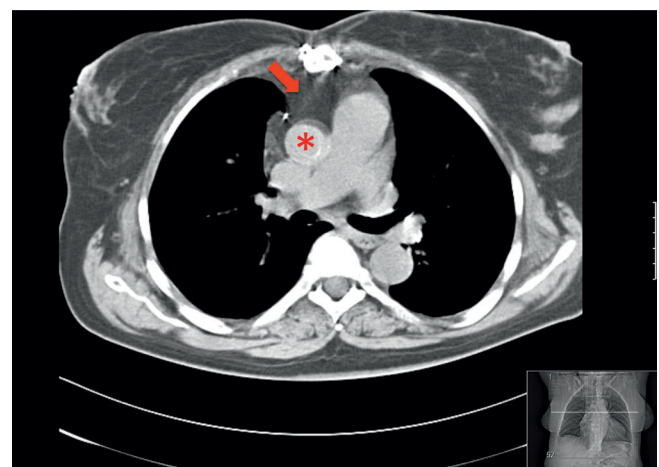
Computed tomography 3 years postoperatively. (Red arrow) The omental wrap. (Red asterisk) The new aortic prosthesis covered by the omentum.
